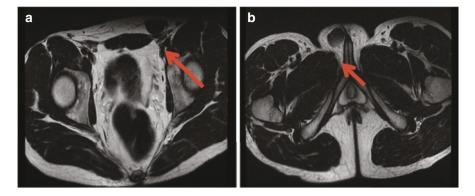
Pelvic MRI of patient with PAIS. (a) Arrow showing left inguinal gonad. (b) Arrow showing right labial/scrotal gonad
